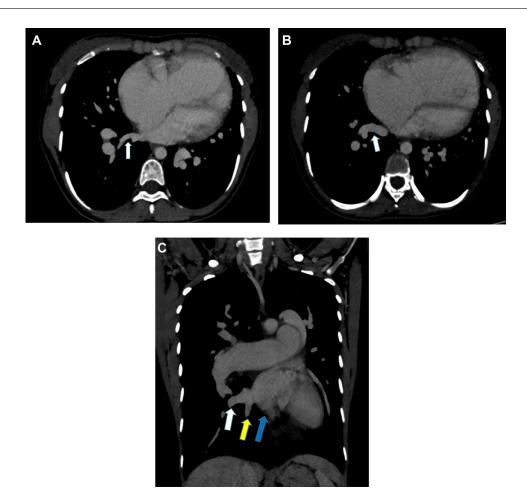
(A) Normal venous drainage of the right superior pulmonary vein (White arrow) into the left atrium (B) Normal venous drainage of the right inferior pulmonary vein (White arrow) into the left atrium (C) Coronal CT showing normal drainage of right pulmonary veins into right atrium with White arrow showing Right superior pulmonary vein, yellow arrow showing right inferior pulmonary vein and blue arrow showing left atrium.
